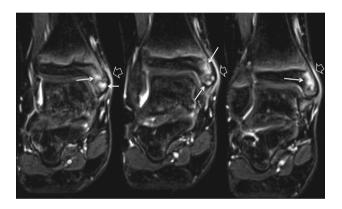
Consecutive coronal fat suppressed T2W MR images, showing multifocal bone marrow edema on both sides of the synchondrosis (arrows). Soft tissue oedema over the medial malleolus is also shown (open arrows).
